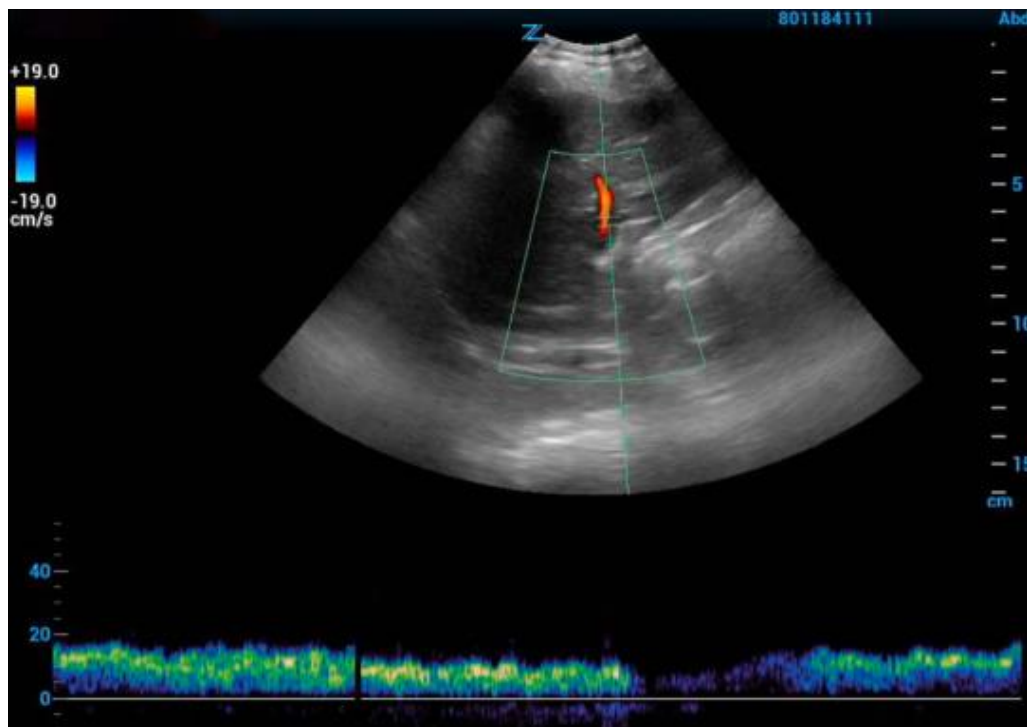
Portal vein doppler with normal grade tracing⁸⁸
